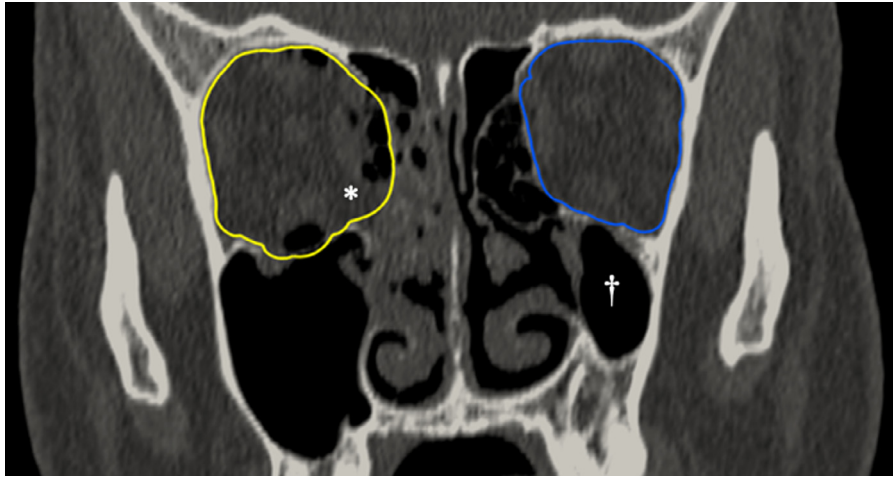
A. 40-year-old patient had right side blowout fracture that was left without surgery. Combined orbital floor and medial wall fracture with notable volume difference of 5.3 mL*. Computed tomography imaging showed a significant asymmetry due to hypoplastic maxillary sinus and zygomatic bone† of unknown aetiology. After 5-week follow up, the patient developed 1-mm enophthalmos that did not disturb the patient.
